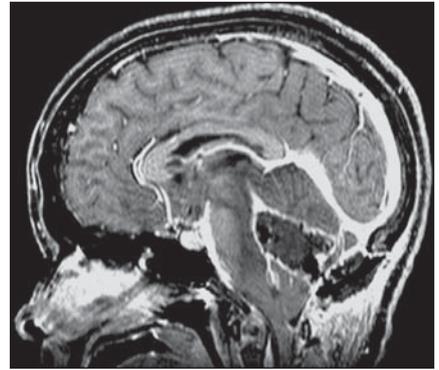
Sagittal, contrast-enhanced MRI, T1-weighted sequence with a better visualization of the continuity of foci with marked hyposignal adjacent to the craniotomy, with the surgical site (air/gas) and within this mass/heterogeneous lesion.
